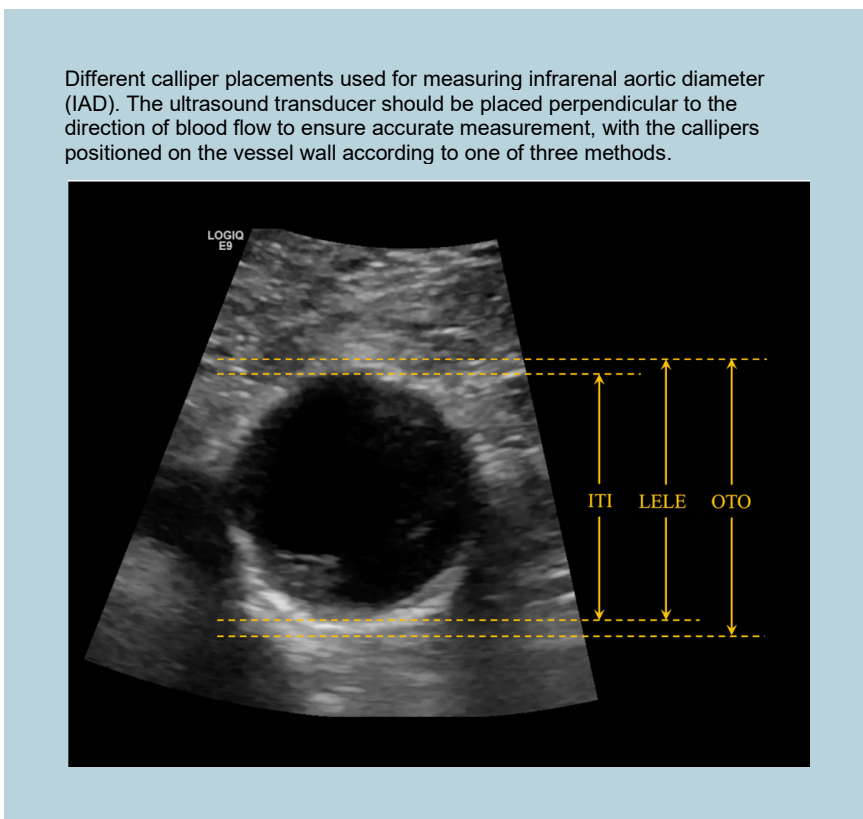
Ultrasound image of infrarenal aorta in the transverse plane. Calliper placement for measurement of aortic diameter. ITI = inner to inner; LELE = leading edge to leading edge; OTO = outer to outer. Photo: Andrea Mosonyi.
